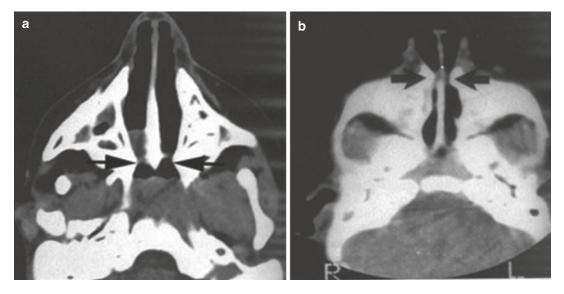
CT scan of the head showing (a) choanal atresia and (b) piriform aperture stenosis. Note the differences in location of these embryologically different but similar clinical nasal obstructions
